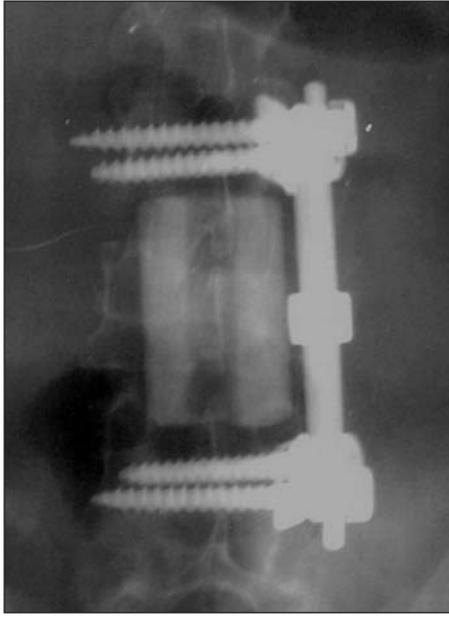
Postoperative X-ray showing the spinal instrumentation.
